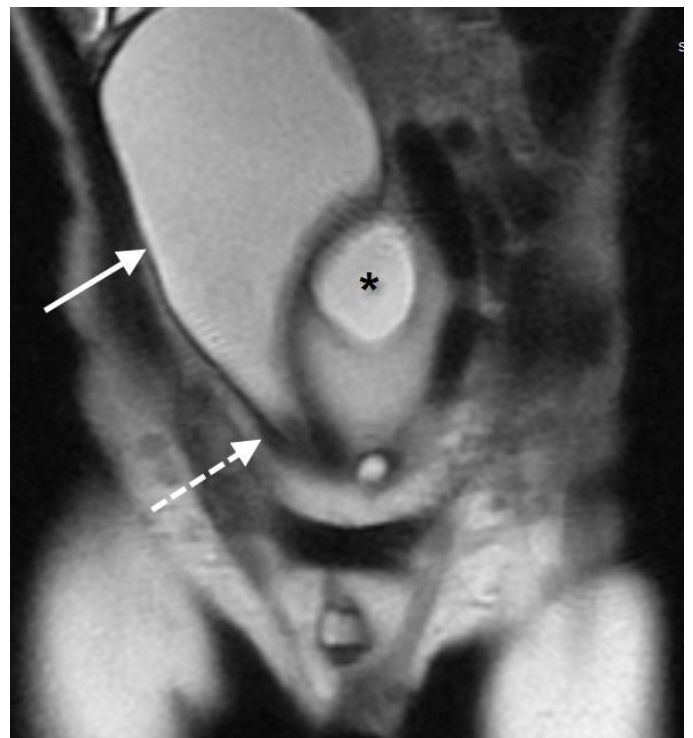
2-year-old male with an anorectal malformation and large anterior sacral meningocele. MRI of the pelvis performed on 1.5 Tesla GE Scanner. FINDINGS: Coronal T2-weighted image of the lower abdomen and pelvis shows the elongated bladder (arrow) being displaced superiorly and to the right by the meningocele (dashed arrow)
